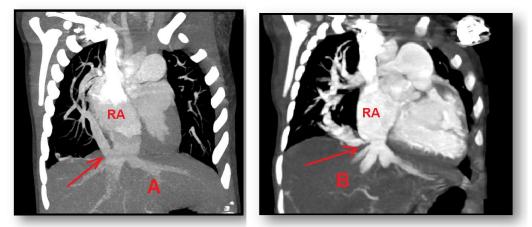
CT Angiography Images Clearly Delineating The Scimitar Vein- Right Upper, Middle, And Lower Lobe Veins Forming A Common Channel (Red Arrow) Draining Into The Suprahepatic IVC At The Level Of The Diaphragm (A); Right-Sided Pulmonary Veins Uniting To Form A Common Channel (Red Arrow) Draining In The IVC At The Level Of IVC- Right Atrium (RA) Junction (B).
